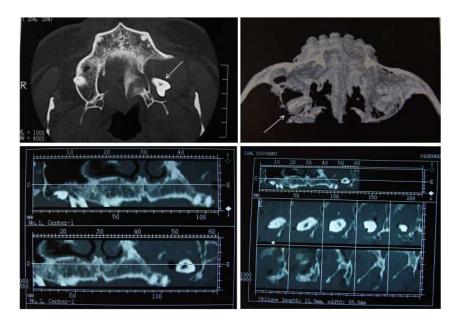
Computed tomography showing tooth 28, pointed by arrows, inside the left maxillary sinus
